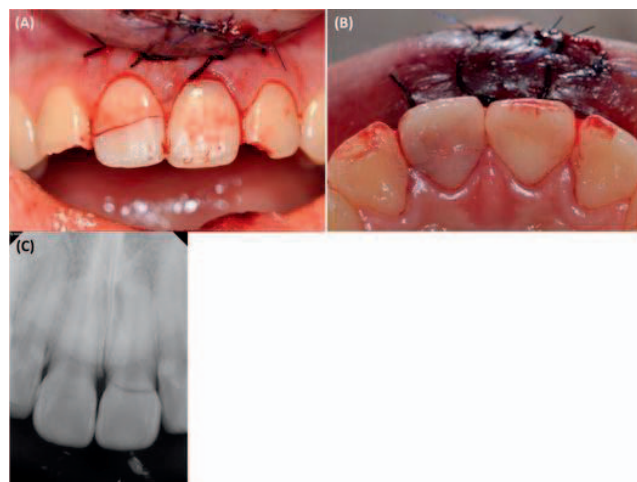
(A, B) Preoperative photographs of fractured teeth (#8, #9) with complicated crown fractures and #7 and #10 with uncomplicated crown fractures. (C) Intraoral radiograph of fractured teeth.
